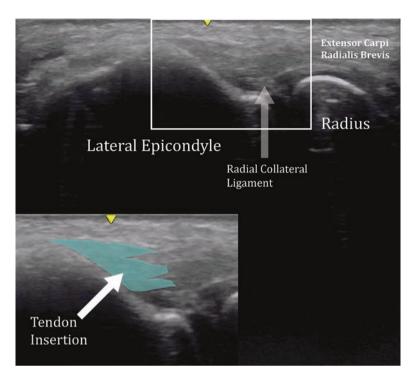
Ultrasound image of the lateral epicondyle
